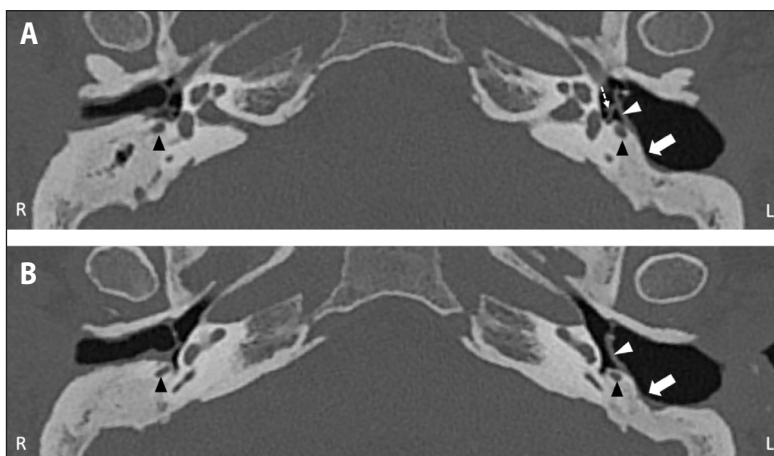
Sequential axial CT images at the level of the modiolus and B. the round window niche. In both images, black arrowheads point to the mastoid segments of the facial nerve on both sides. On the unoperated right side, a thick layer of mastoid cortical bone overlies the facial nerve. On the operated side, only a thin layer of bone overlies the facial nerve, such that the floor of the mastoid cavity (white block arrows) does not have a high ridge of bone separating it from the middle ear space. In both images, a neotympanum of cartilage (white arrowheads) extends from the anterior EAC wall to the facial ridge, effectively sealing off the middle ear space, eustachian tube, and nasopharynx, from the mastoid cavity and ear canal. Additionally, the stapes superstructure (white dashed arrow) can be seen touching the cartilage neotympanum in Figure 3A, demonstrating a type III tympanoplasty.
